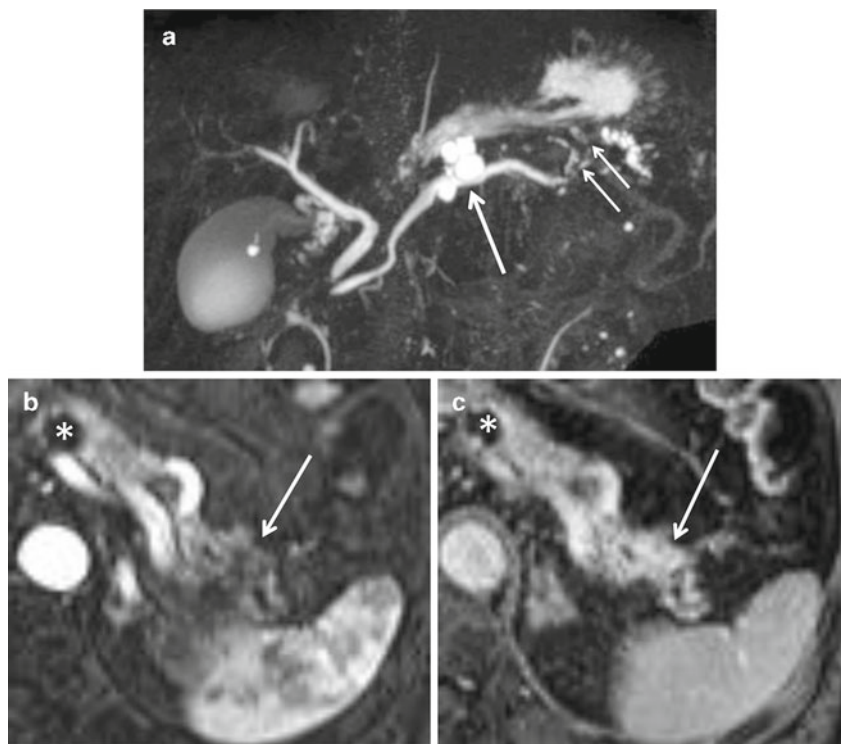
Pancreatic ductal adenocarcinoma in the pancreatic tail with concomitant BD-IPMN (adenoma) in the pancreatic body. (a) MIP image of 3D-MRCP shows BD-IPMN in the pancreatic body (*large arrow*). Additionally, obstruction of the MPD and upstream MPD dilatation are noted (*small arrows*). (b) The arterial phase of axial dynamic MRI shows a hypointense lesion (*arrow*) in the pancreatic tail that corresponds to the area of MPD obstruction noted on MRCP. *Asterisk* indicates BD-IPMN. (c) The equilibrium (delayed) phase of axial dynamic MRI demonstrates the pancreatic tail lesion to show delayed enhancement, consistent with pancreatic cancer (*arrow*). *Asterisk* indicates BD-IPMN
